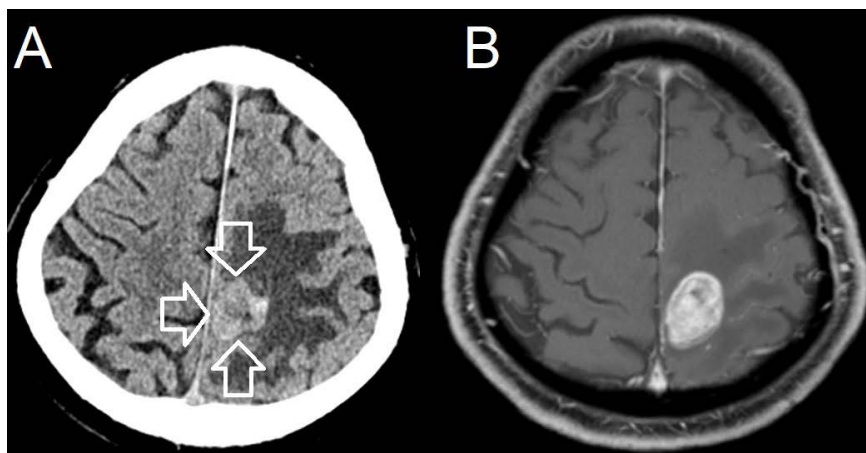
Metastatic melanoma. A 75-y/o with 3 weeks of right-sided weakness, unable to bear weight due to right leg buckling. The patient was unable to write with the dominant right hand. (A) CT demonstrates hyperdensity (arrows) with surrounding vasogenic edema, and (B) mostly homogeneous enhancement on brain MRI.
